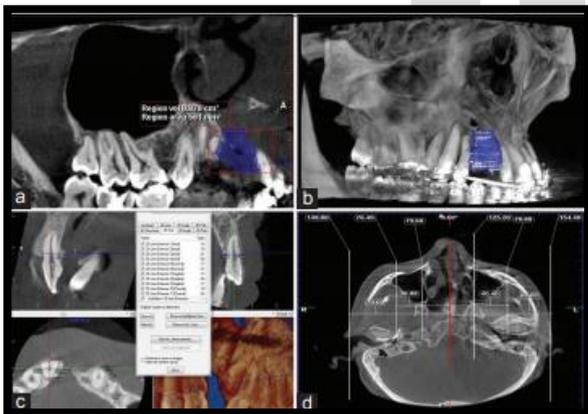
CBCT in the assessment of craniofacial structures in patients with CLP. (a) CBCT in the assessment of volume of cleft defect, (b) CBCT in the assessment of ABG, (c) CBCT in the assessment of ABT, (d) CBCT in the assessment of facial asymmetry in axial slice. CBCT: Cone-beam computed tomography, CLP: Cleft lip and palate, ABG: Alveolar bone grafting, ABT: Alveolar bone thickness.
